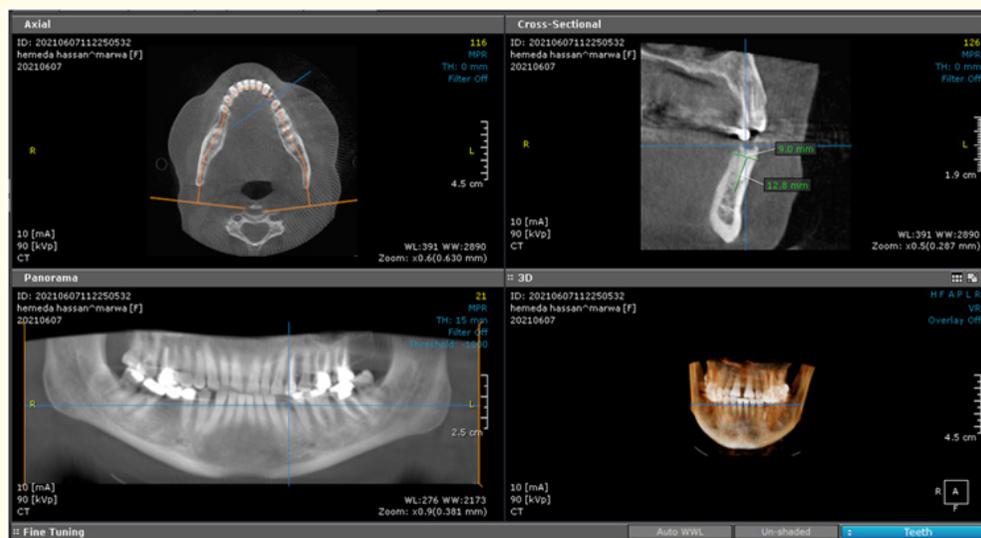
Photograph showing CBCT to detect bone width and length at the interested area.
